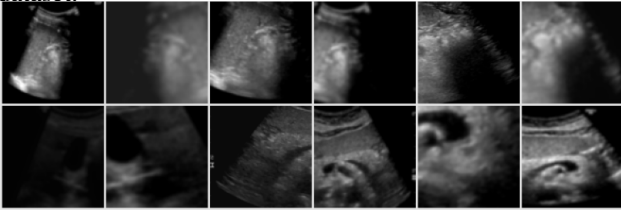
Augmented image pair samples of the abdominal ultrasound unlabeled dataset
